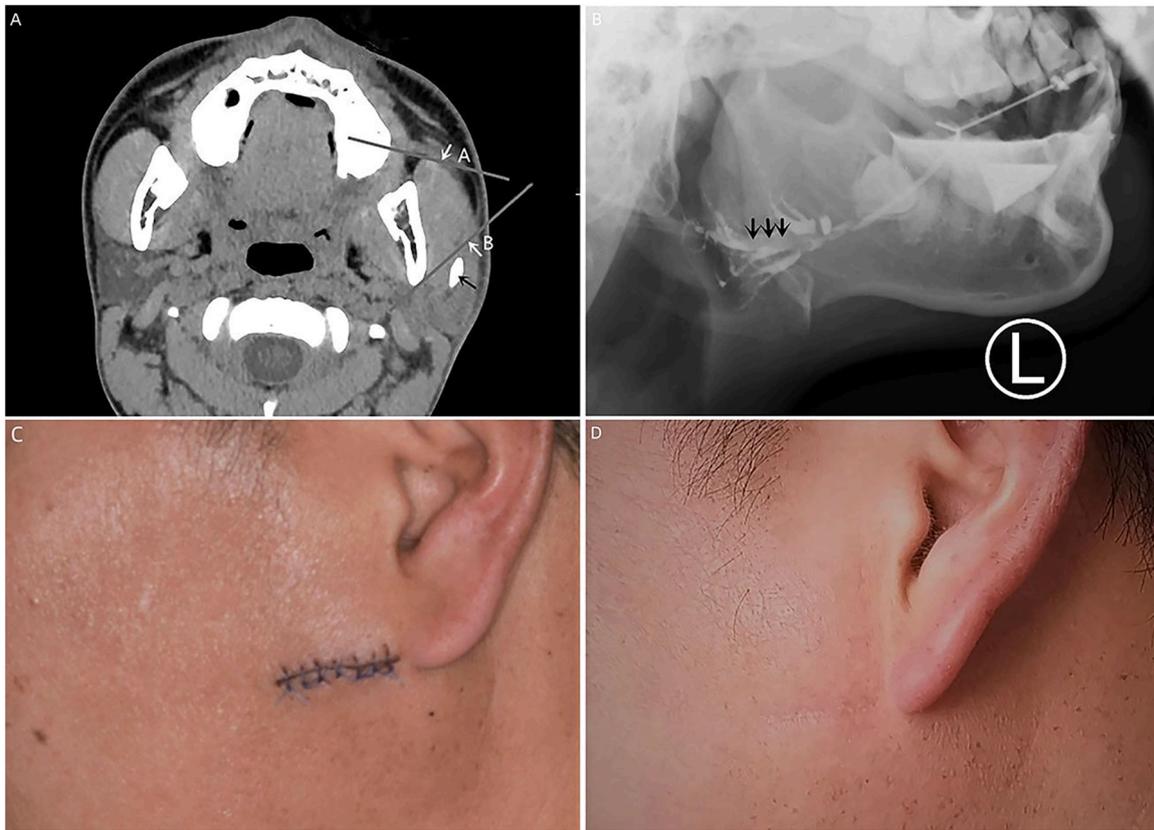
The case of a 34-year-old man with a 2-year history of a left parotid gland stone. (A) Axial computed tomography showed a 15-mm stone (black arrow) in the intraglandular duct. Sites A and B (white arrow) were marked. (B) Preoperative sialography revealed a filling defect of the main duct at the stone site (black arrow) and ectasia of the branch ducts. (C) The stone was removed via a 20-mm horizontal incision near the earlobe. (D) Four years after surgery, the affected gland had good function, and the scar was nearly imperceptible.
